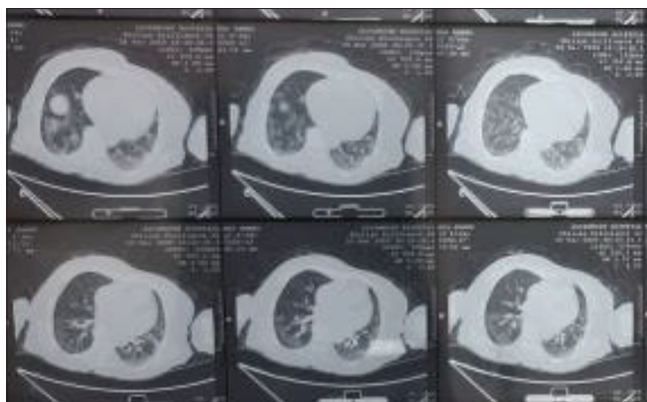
Initial chest computed tomography scan showing bilateral ground-glass infiltrates (in the first hospital)
